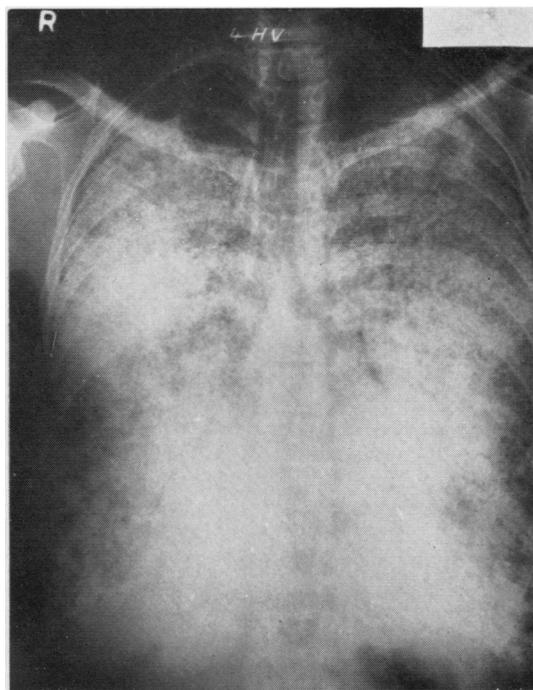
Overpenetrated chest radiograph.
